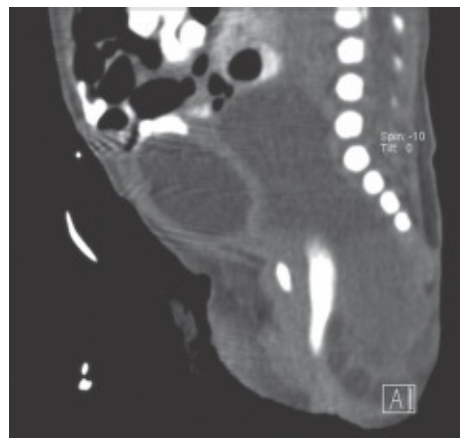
• Postnatal SCT imaging. Postnatal CT scan demonstrating a predominantly type II SCT.
